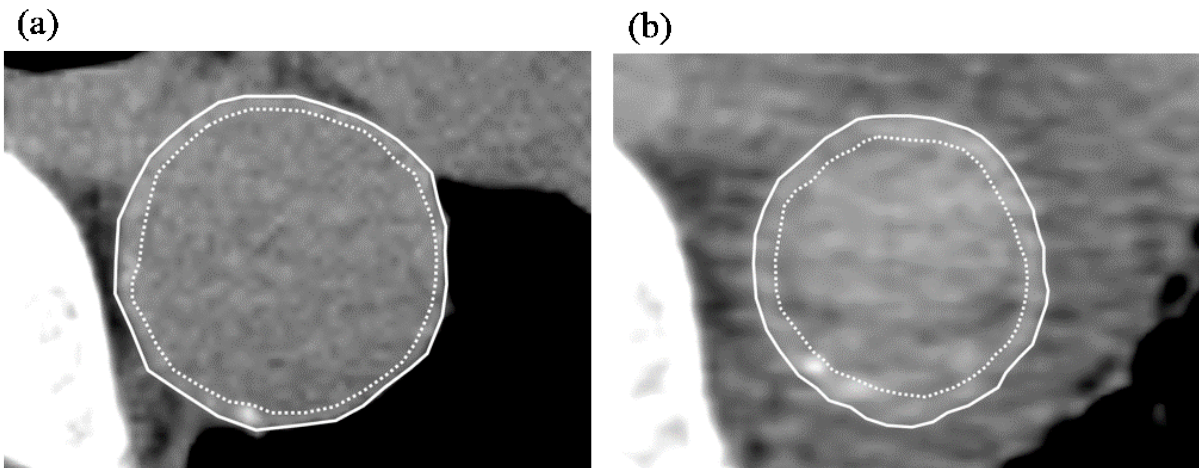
CT image showing the two cross-sectional aortic measurements obtained on antemortem and postmortem CT: the area within the inner aortic wall (dotted line) and the area within the outer aortic wall (solid line).
